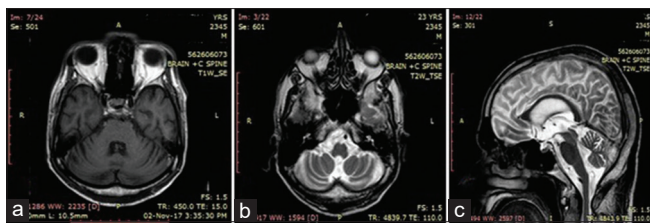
(a and b) Magnetic resonance imaging brain axial sections (T1-weighted image and T2-weighted image) and (c) sagittal section (T2-weighted image) suggestive of diffuse cerebellar atrophy
